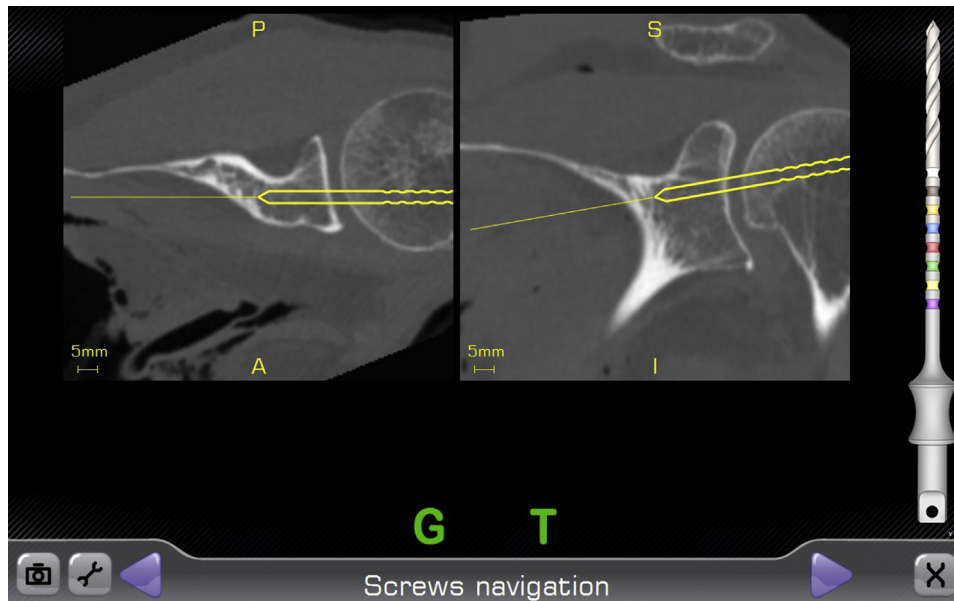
The ExactechGPS navigation screen is shown, demonstrating the real-time, intraoperative drill bit trajectory in relation to the patient's scapula, rendered from a preoperative computed tomography scan.
